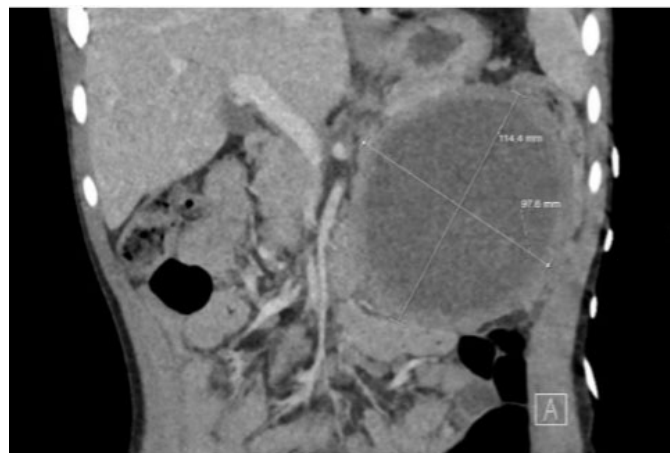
CT coronal view 114 mm × 97 mm retroperitoneal cystic mass displacing the left colon, pancreas, and small bowel.
